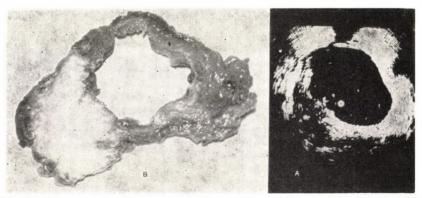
$U_4$ : Intravesical ultrasonogram of an extravesically invading tumour situated on the right lateral wall of the bladder. The irregular echo-structure reaches beyond the bladder contour and a looser echo-pattern of peripherally weakening intensity can be visualized. B. The cancer tissue has penetrated into the bladder wall and is attached to the surrounding tissue
